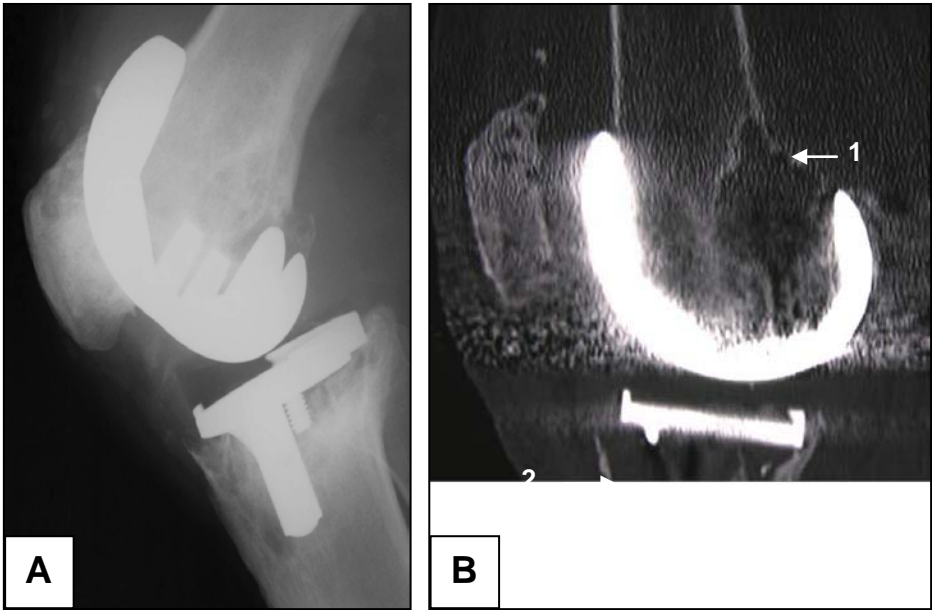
Assessment of TKR for periprosthetic osteolysis by A, plain radiography and B, computed tomography. Shown is B1, femoral and B2, tibial periprosthetic osteolysis (arrows).
